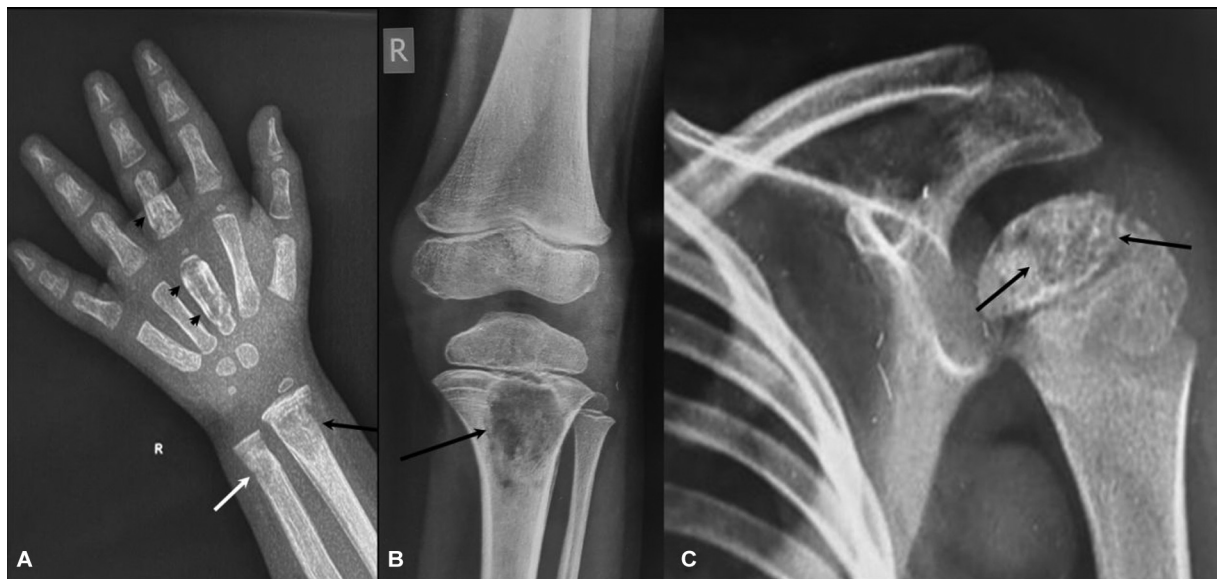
Chronic nonbacterial osteomyelitis (CNO) in a 4-year-old male who complained of recurrent pain in bilateral wrists and right knee. (A) Posteroanterior (PA) view radiograph of the right wrist reveals an ill-defined lytic lesion in metaphyses of right distal radius with focal thinning and rarefaction of the medial cortex (black arrows, A), another similar lesion in distal ulna (white arrows, A) with hyperostotic lesions in metacarpals and phalanges of right 3rd digit (arrowheads, A). Frontal radiographs of right knee (A) and left shoulder show similar lytic lesions in proximal tibia (arrow, B) and proximal humerus (arrows, C).
